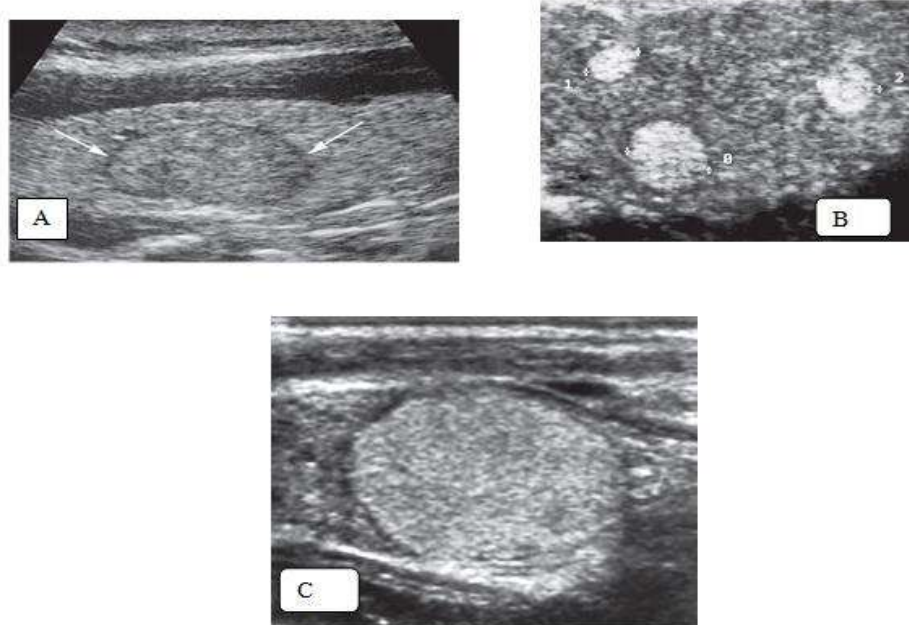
Hyperplastic (adenomatous) nodule. Longitudinal ultrasound images. A, Oval homogeneous nodule) (arrows) with thin, uniform halo. B, Three hyperechoic nodules, typical of hyperplasia. C, Solitary hyperechoic nodule, which was (benign on fine-needle aspiration biopsy).
